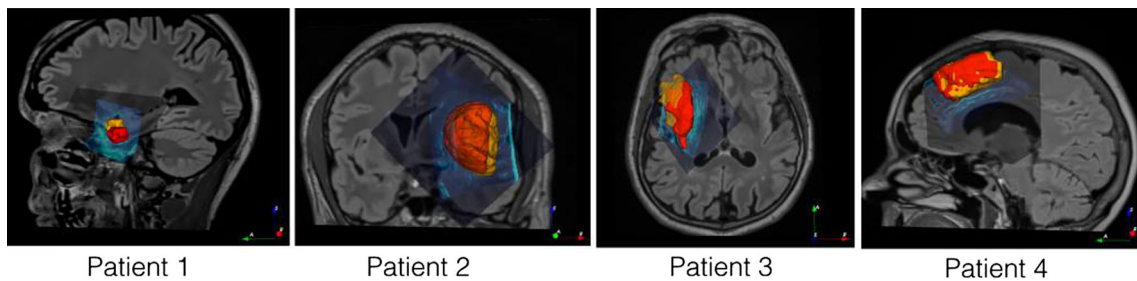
Demonstration of tumor deformation after craniotomy. Tumors before and after deformation are shown as semi-transparent yellow and red 3D mesh objects, respectively. The ultrasound scan (in cyan color
